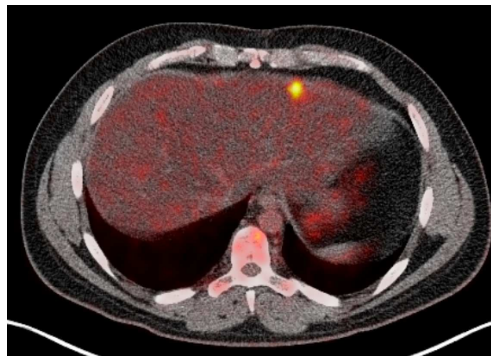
PET-CT image pair depicting liver cancer.
